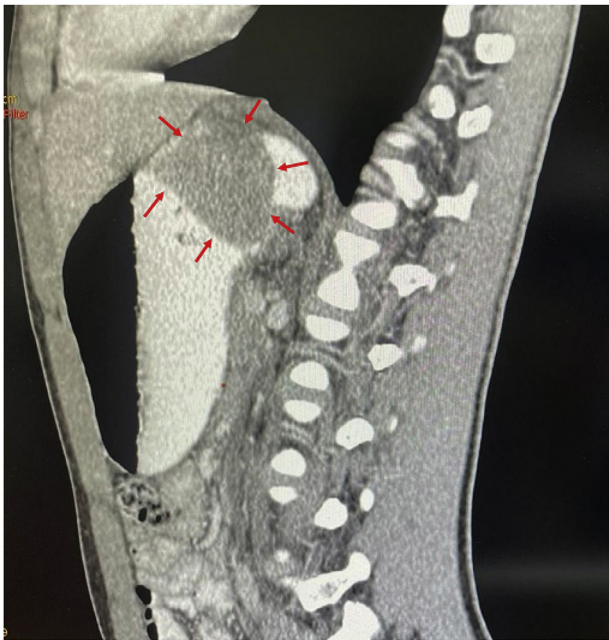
Sagittal view of a computed tomography scan, with oral and intravenous contrast media, showing a cardia-dependent tumor occupying the gastric fundus.
